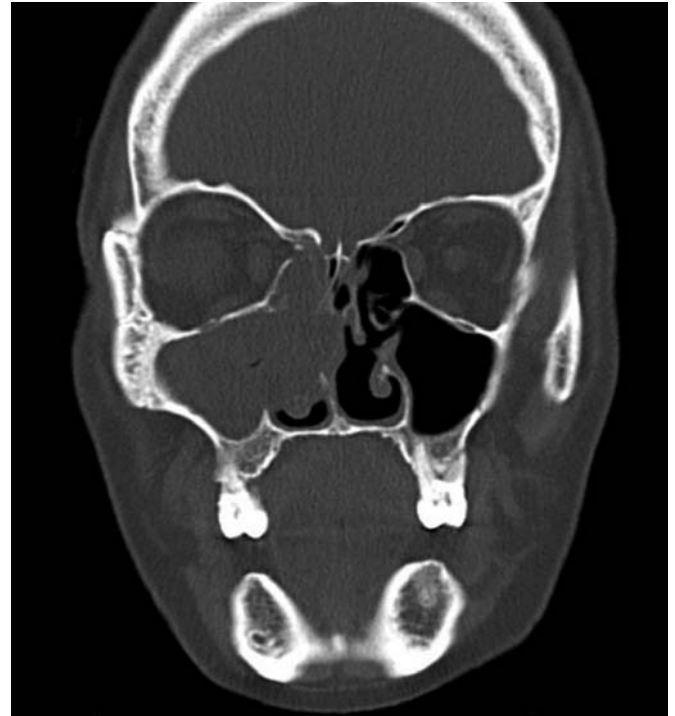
Coronal CT showing chronic fungal sinusitis in the right nasal cavity.
